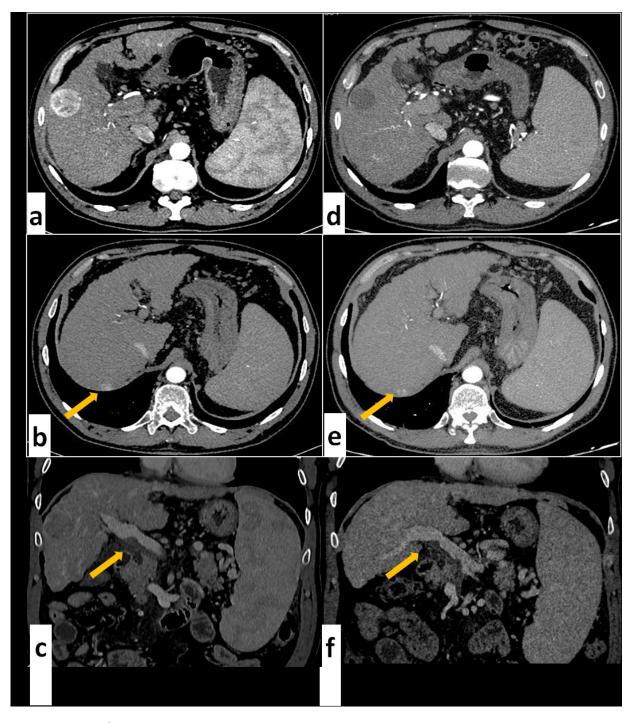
C.G.G, \Diamond , 52yo. Patient with advanced multinodular HCC: main lesion of 3.7 cm in sV (a) and 1 cm in sVII (*arrow in b*) with concomitant neoplastic portal vein thrombosis (c). Two right lobar DSM-TACE were performed with a 4-weeks interval. 6-months CT control (d-f) demonstrated complete necrosis of the main nodule in sV and of the multiple nodules in the right lobe and stability of the lesion in the sVII segment (e) and of the portal vein thrombosis (f). We obtained a substantial downstaging of disease and the patient underwent liver transplant.
